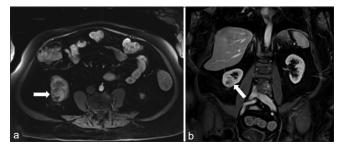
An 82-year-old female who presented for routine surveillance imaging of a renal mass. Post-contrast axial (a) and coronal (b) T1 MRI imaging of the lower pole of the right kidney shows 3.7 cm enhancing solid renal neoplasm (arrows).
